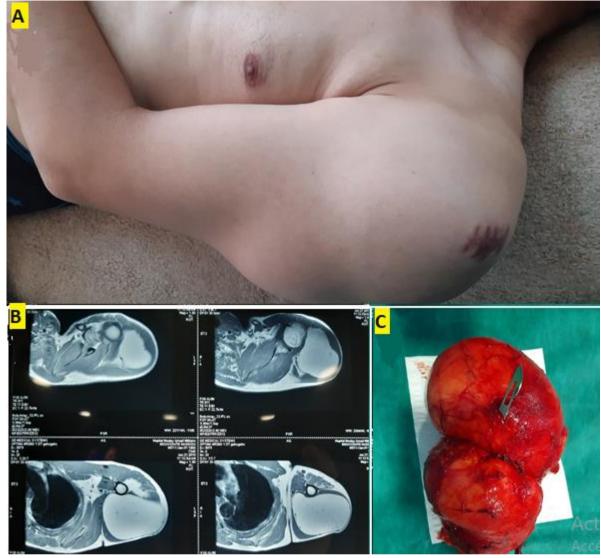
(A) giant lipoma of the left shoulder; (B) left shoulder MRI showing a giant lipoma without signs of malignancy or of vascular nerve compression; (C) intraoperative image showing the tumor which was dissected out and excised en masse
